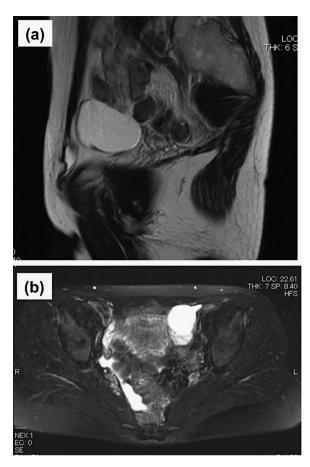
(a) Sagittal T2-weighted MR image showed that a fluid-intensity tumor led to the inguinal canal. (b) Enhanced T2-weighted MRI revealed no solid component within the cystic tumor in contact with the ovary.
